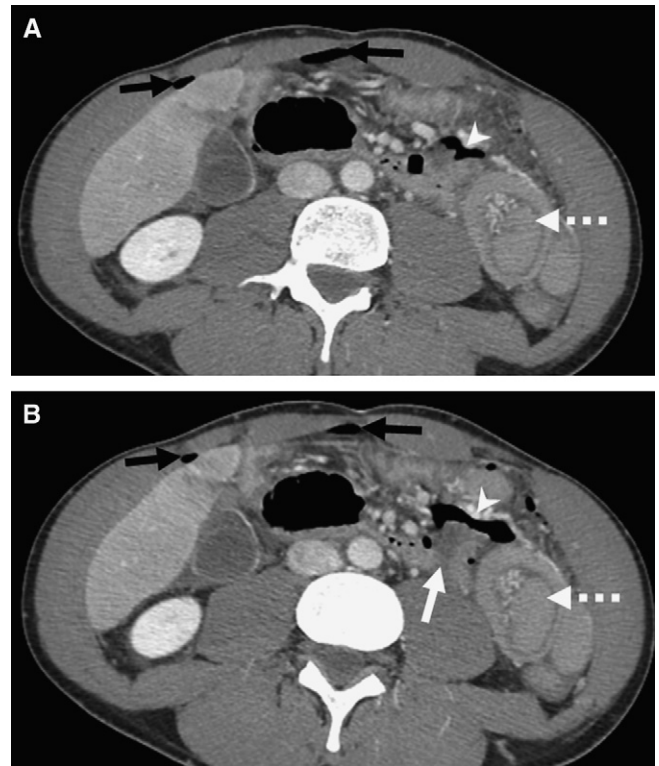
Bowel perforation at the ligament of Treitz in a 55-year-old woman after a motor vehicle accident. (A, B) Axial computed tomography image, showing a suspicious defect (white arrow) with focal fluid and extraluminal air (arrowhead) adjacent to the duodenojejunal junction. There also is free pneumoperitoneum (black arrows). There is a posttraumatic jejunojejunal intussusception (dashed arrow). The patient later underwent resection of a 9-cm segment of the small bowel and manual reduction of the intussusception.
